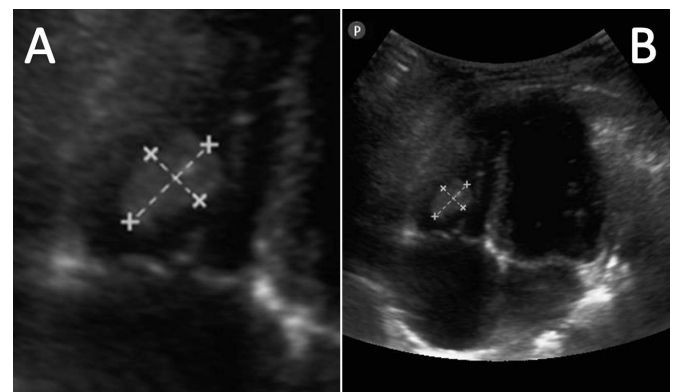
Bedside echocardiography with the convex probe. A, Tumor in the right ventricle (13.9 × 8.4 mm). B, Apical 4-chamber view.
